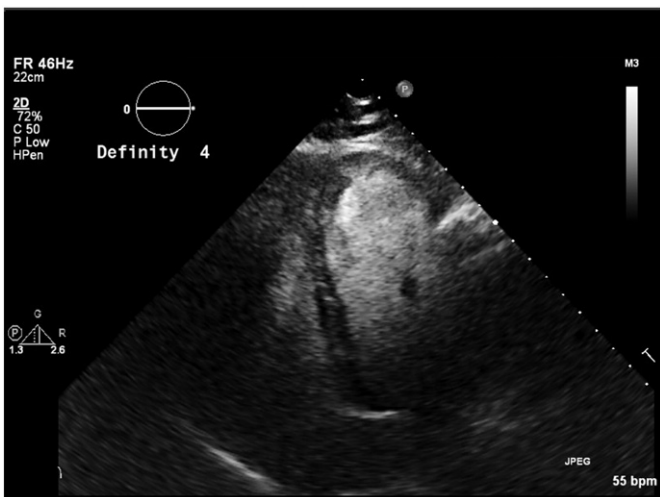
Apical 4-chamber view on 2D echocardiogram following intravenous definity contrast demonstrating apical thrombus.
